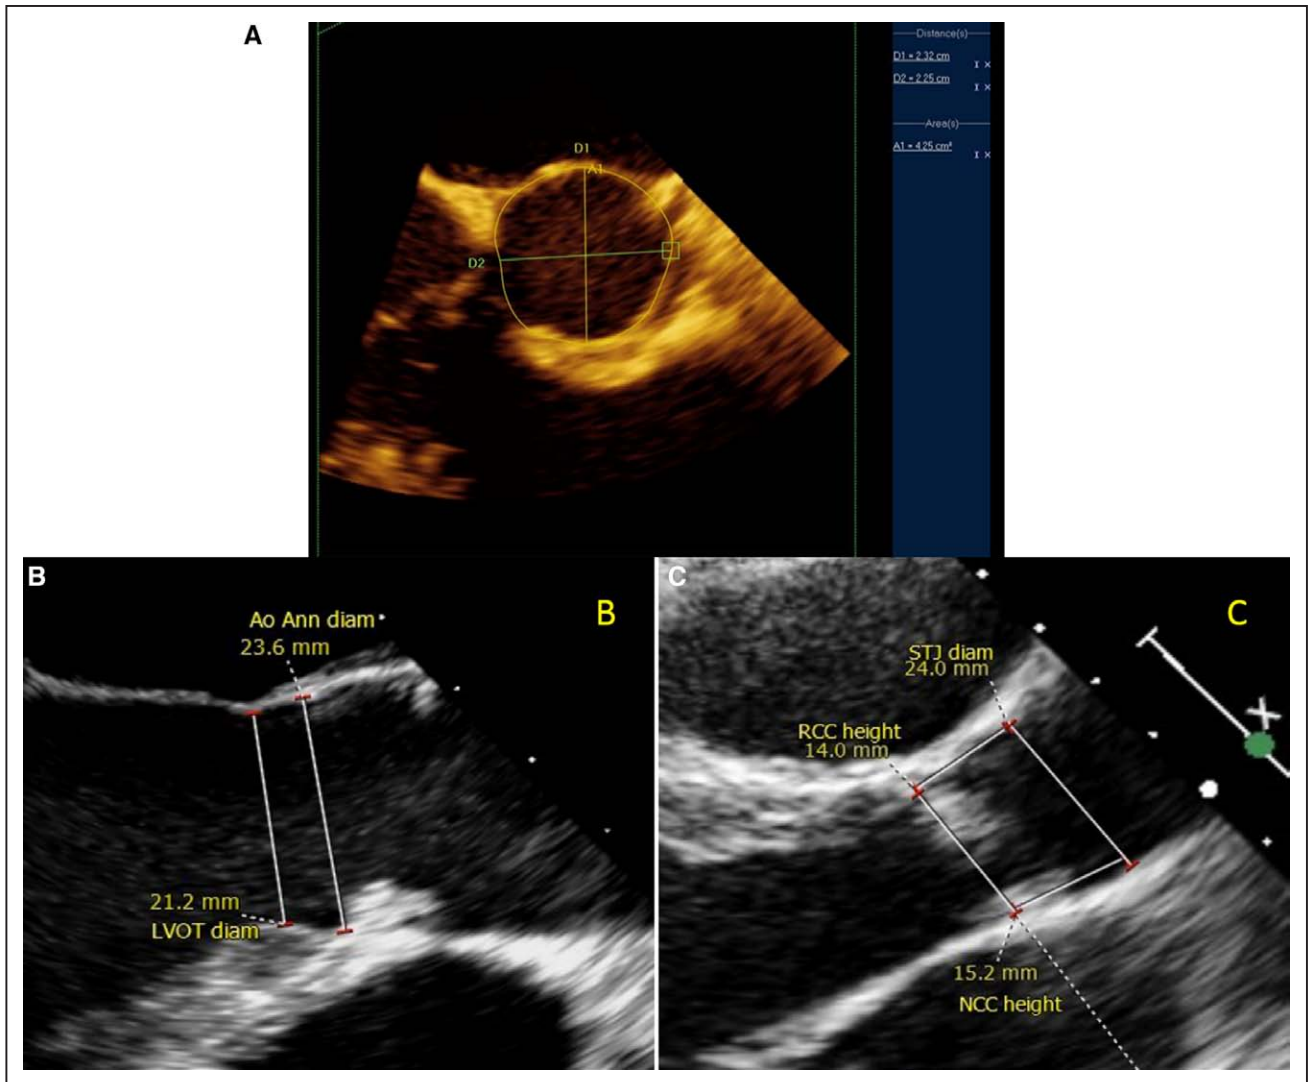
Preoperative 3D transesophageal echocardiogram images. A, Aortic annulus diameter (Ao Ann diam; 23.2×22.5 mm) and annulus area (425 mm²). B, Aortic annulus diameter (23.6 mm) and left ventricular outflow tract diameter (LVOT; 21.2 mm). C, Sinotubular junction diameter (STJ diam; 24 mm). NCC indicates noncoronary cusp; and RCC, right-coronary cusp.
